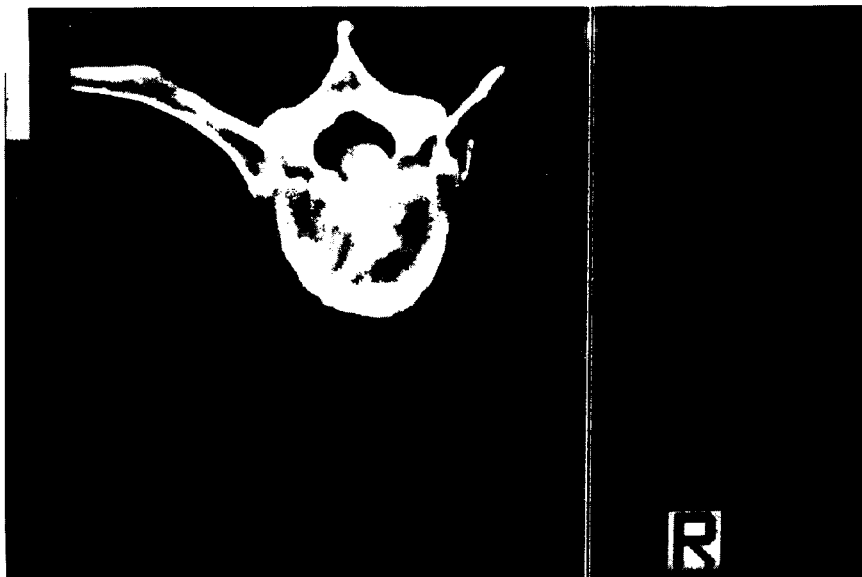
Case 2. CT scan of dorsal spine showing rounded calcified mass occupying much of spinal canal and associated calcification within disc material.
